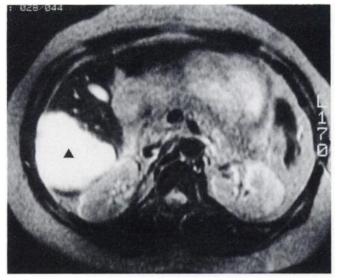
T2-weighted transverse magnetic resonance image of the abdomen demonstrates an 8-cm high intensity mass (triangle) in the posterior aspect of the right lobe of the liver.
